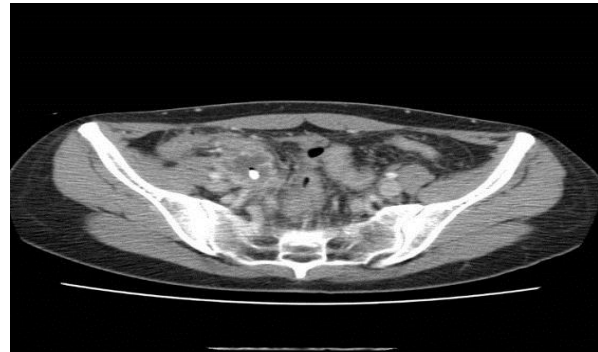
U S Show Appendicular abscesses      Figure 4: CT scan show appendicular abscesses
